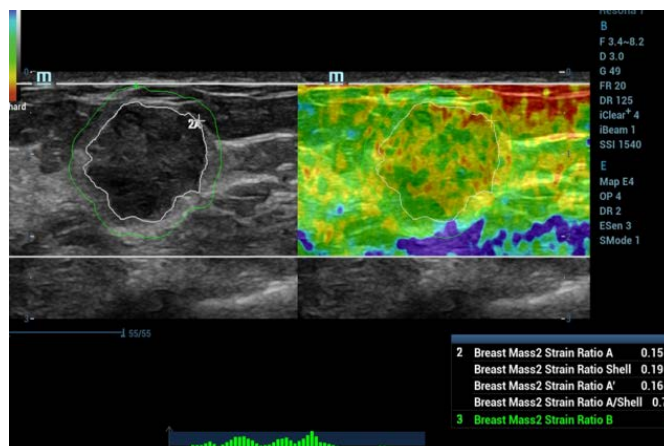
Ultrasound elastography of benign breast mass, BIRADS=3, with scoring value = 0.7 SR
